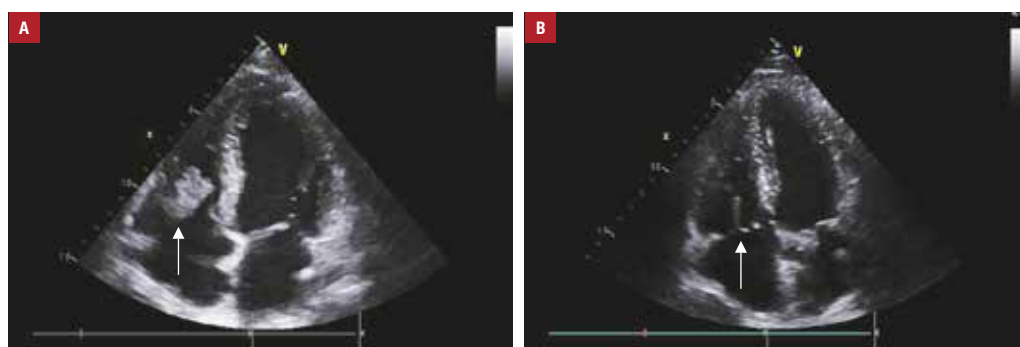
Transthoracic echocardiogram (4-chamber view): A – a mass on the tricuspid valve (arrow); B – a CorMatrix tricuspid valve (arrow)
